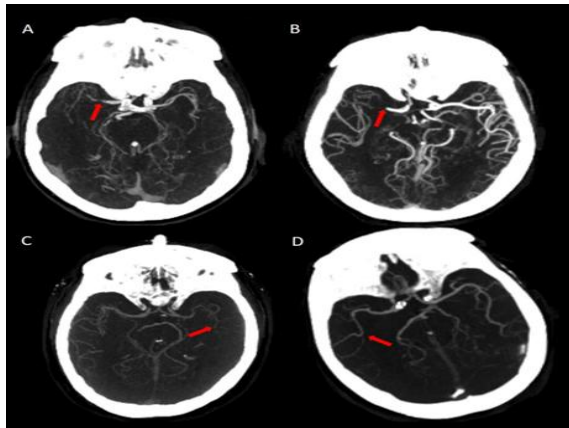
CT angiography demonstrating abrupt cut-off of the middle cerebral artery consistent with large vessel occlusion.
